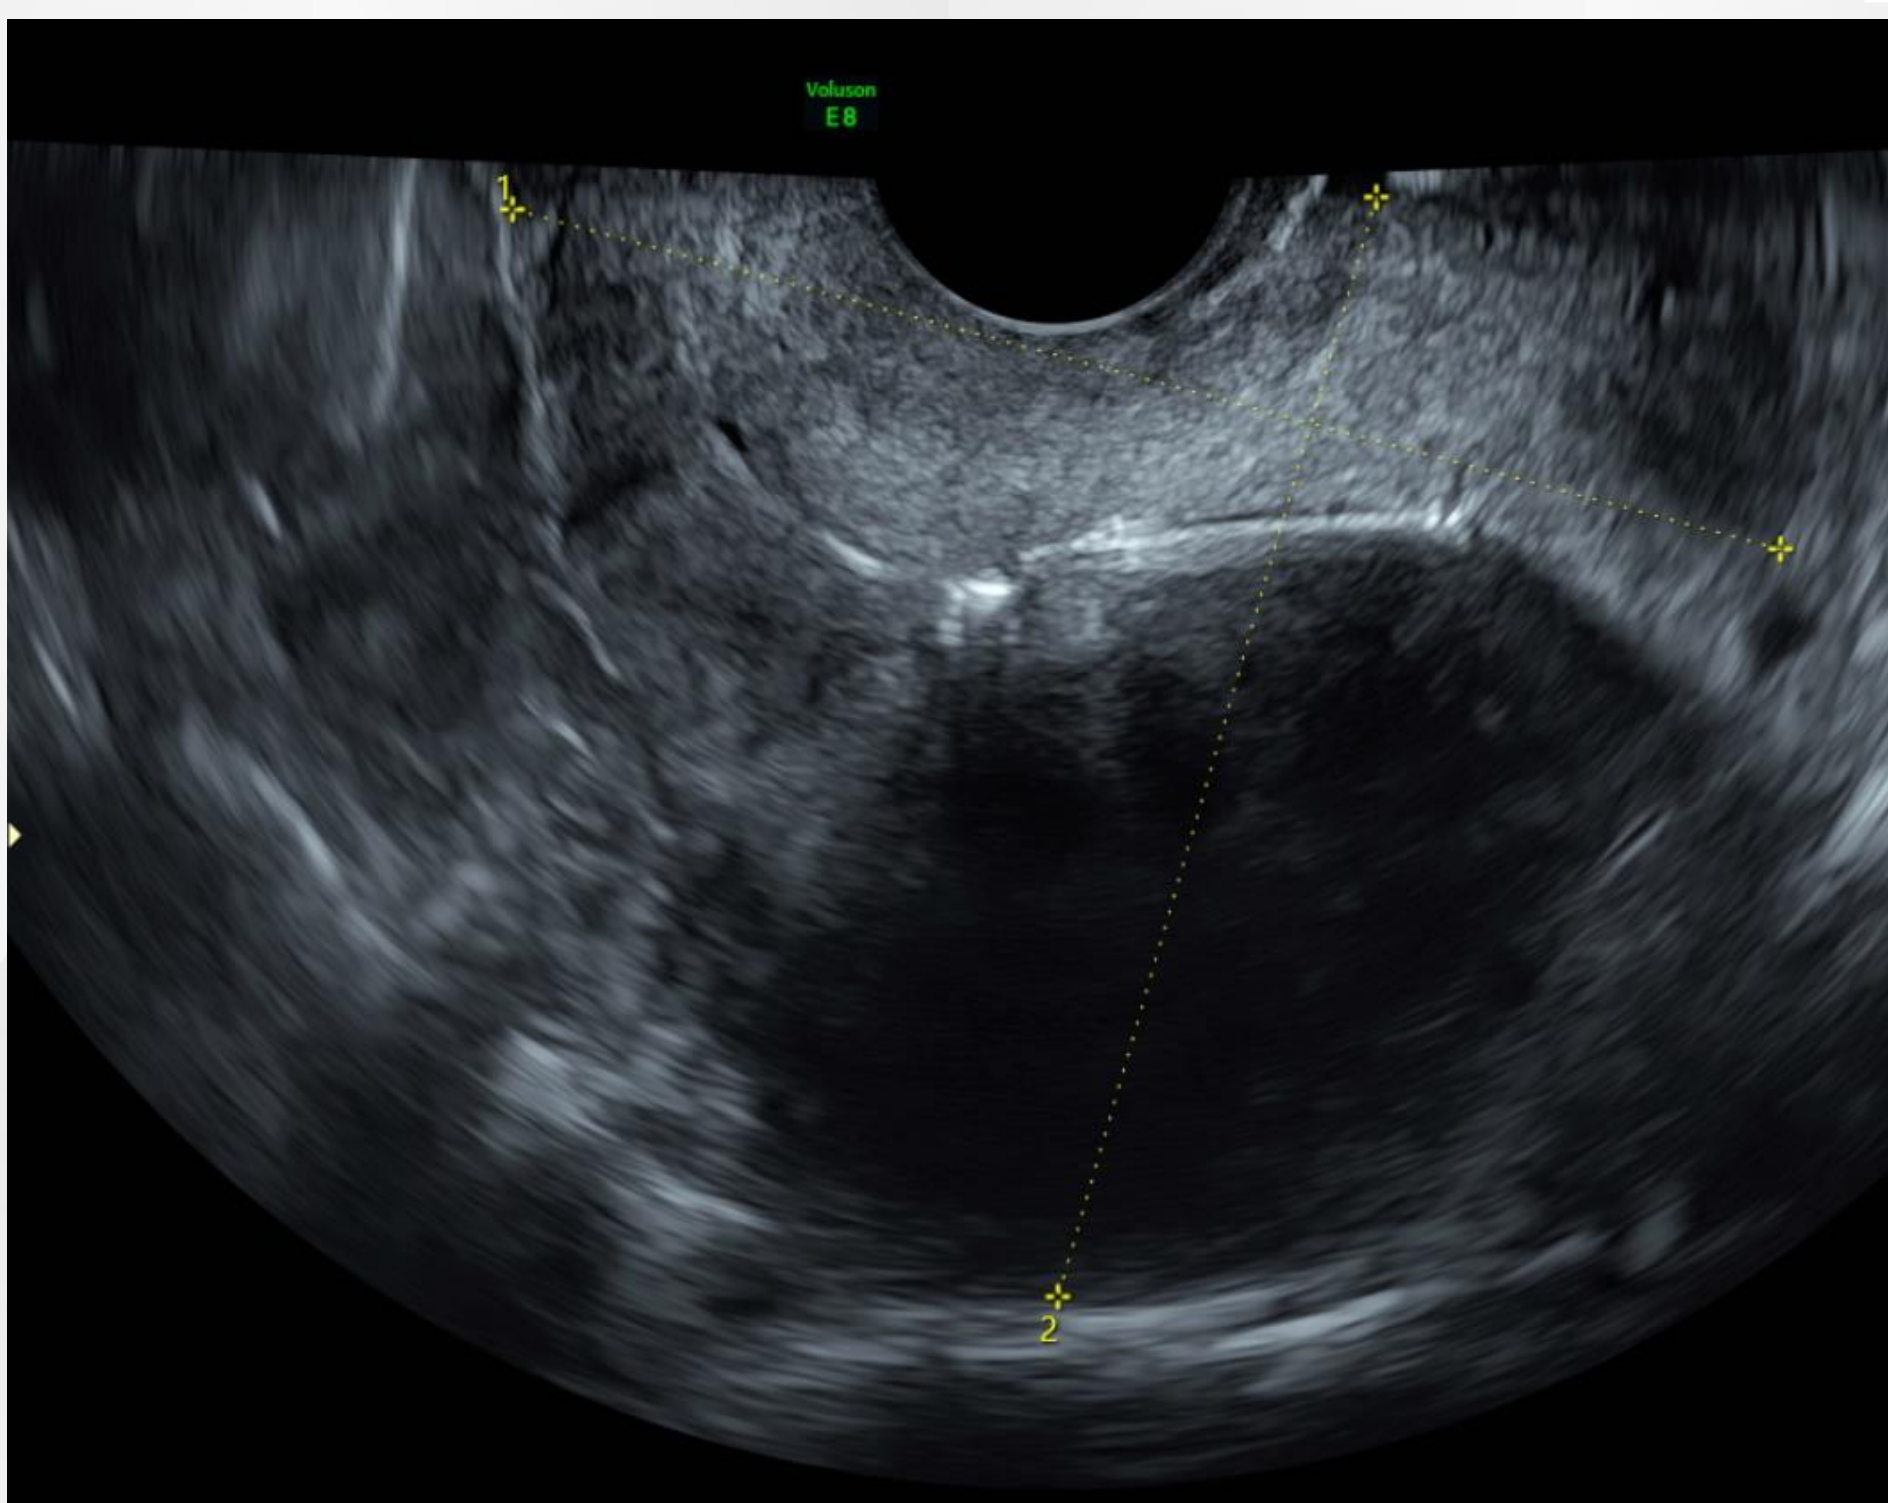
Ultrasound image showing the longitudinal section of the uterus with the visualisation of 1 coil within the midline.
